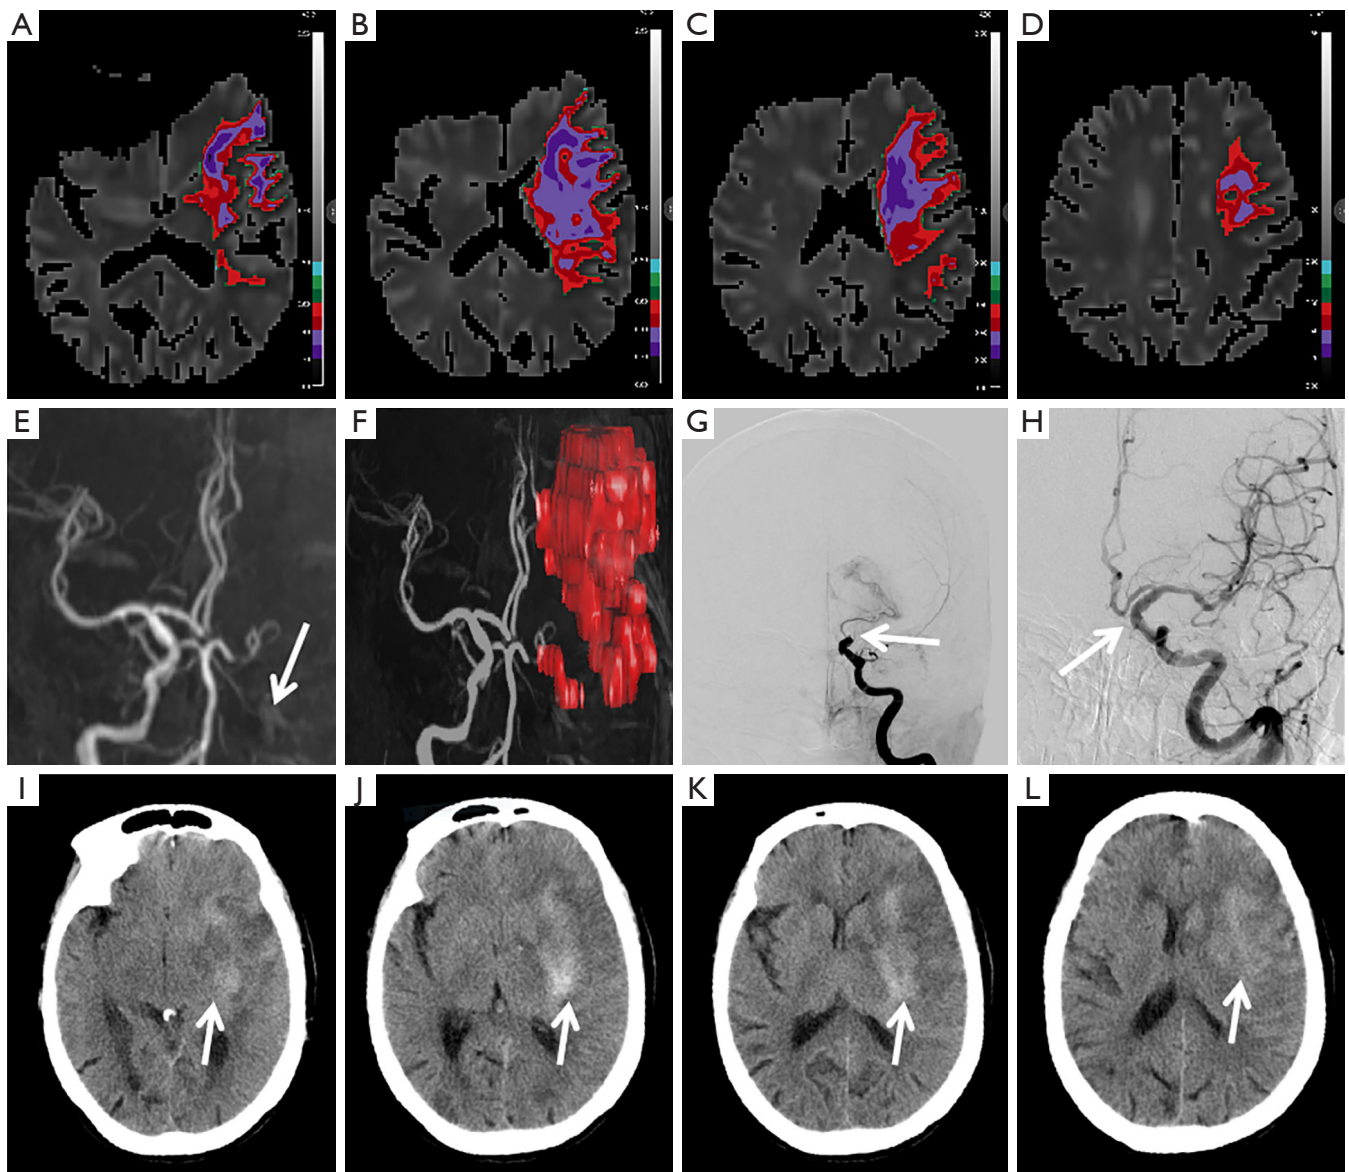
Imaging of a patient with HI2. (A-D) Preoperative ADC map showing the ADC value distribution in the infarct core. The severity of the ischemic area is represented by different colors with the related ADC value range (unit: $10^{-3} \text{ mm}^2/\text{s}$): bright red, 0.5–0.6; dark red, 0.4–0.5; light purple, 0.3–0.4; and dark purple, <0.3 . The volume (unit: ml) of the areas with ADC <0.4 is 20.33. (E) MRA image before EVT showing left internal carotid artery (LICA) occlusion (white arrow). (F) Image fusion using MRA and DW images. DSA image before (G) and after (H) EVT showing LICA occlusion (mTICI 0) (G, white arrow) and complete recanalization (mTICI 3) (H, white arrow). (I-L) Follow-up CT showing petechial hyperdensity throughout the wedge-shaped hypodensity in the territory of the left middle cerebral artery (white arrows), which indicates HI2. HI, hemorrhagic infarct; ADC, apparent diffusion coefficient; MRA, magnetic resonance angiography; EVT, endovascular therapy; DW, diffusion weighted; DSA, digital subtraction angiography; LICA, left internal carotid artery; mTICI, modified Thrombolysis in Cerebral Infarction scale; CT, computed tomography.
